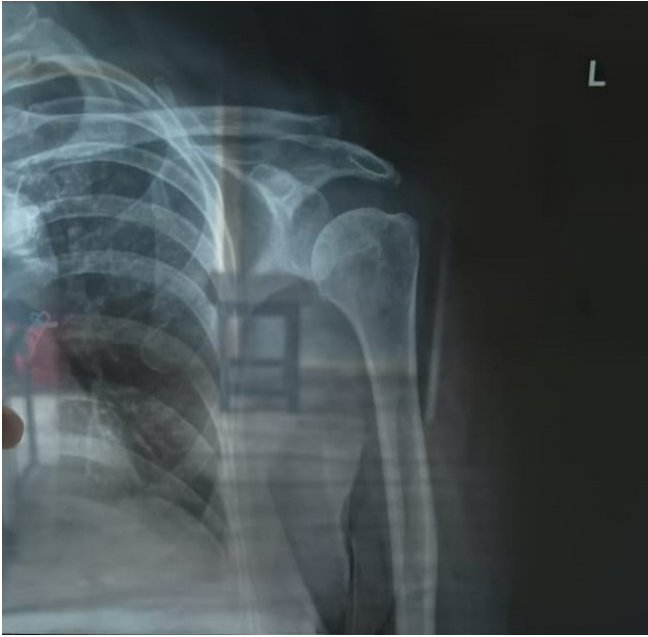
X-ray at admission
